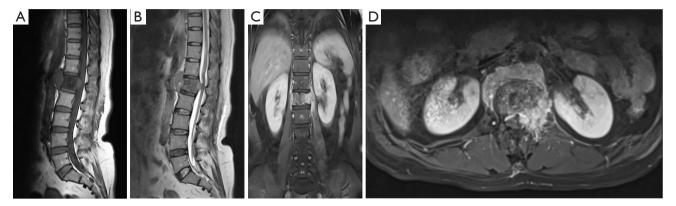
Preoperative MRI of the lesion. Sagittal MRI showed an abnormal signal of L1 vertebra on T1WI (A) and T2WI (B) with the destruction of vertebral bodies and adnexal bone. Coronal (C) and axial (D) contrast-enhanced MRI showed abnormal enhancement signal. MRI, magnetic resonance imaging; T1WI, T1-weighted image; T2WI, T2-weighted image.
